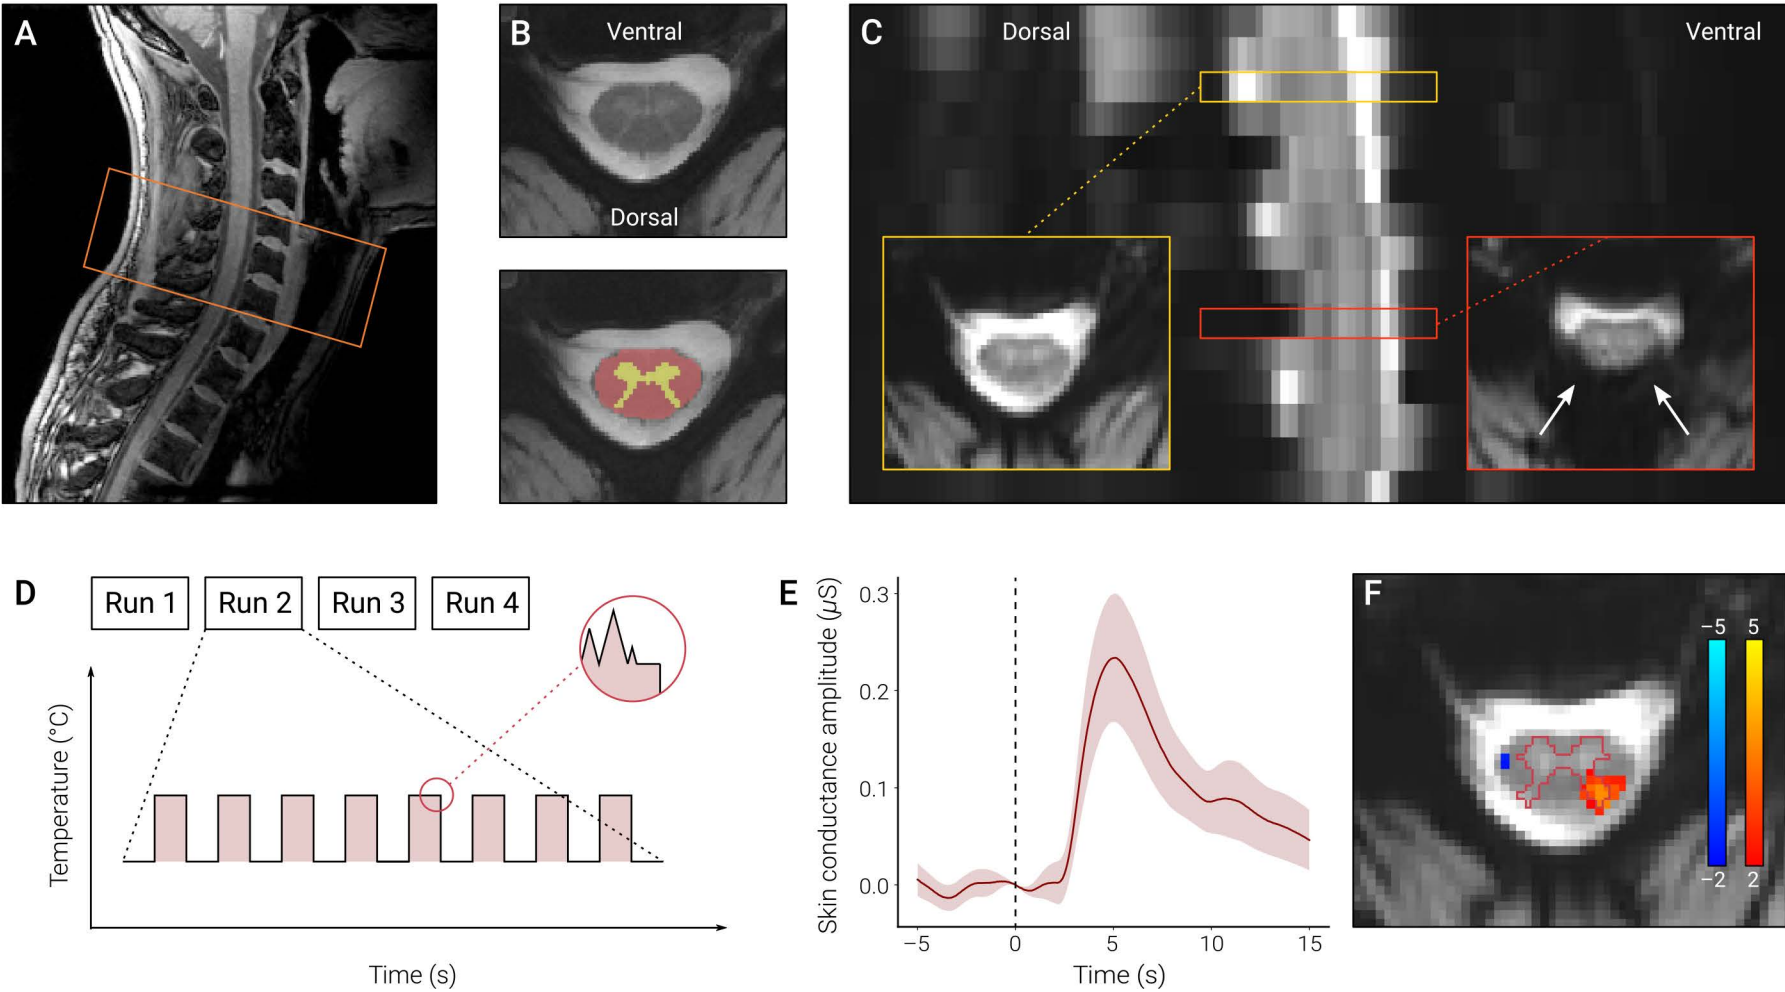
(A) Mid-sagittal section of a T1-weighted acquisition (resolution: 0.8 mm isotropic) of a representative participant, with the EPI field-of-view depicted in orange. (B) Transversal section of a structural T2*-weighted acquisition (in-plane resolution 0.38 x 0.38 mm) used to segment the spinal cord’s white matter (red) and grey matter (yellow). (C) Mid-sagittal section of transversally acquired EPI data (fifteen 3 mm-thick slices, TR = 1120 ms, TE = 23 ms, GRAPPA acceleration factor: 3, in-plane resolution: 0.75 x 0.75 mm), with insets depicting slices with adequate data quality (yellow) and insufficient data quality (red; signal loss indicated by arrows). (D) Experimental paradigm (4 runs), consisting of a 30 s ON-OFF block design using eight painful heat stimuli (with superimposed pseudorandom heat-spikes of different amplitude, frequency 1 Hz). (E) Painful heat stimulation resulted in prominent autonomic nervous system activation as assessed by concurrently recorded skin conductance responses. (F) BOLD response to painful heat stimulation at the level of a single participant, with colour bars indicating t-values. The response is overlaid on the mean functional image, with activation being present in the dorsal horn ipsilateral to the stimulation side and the activation peak falling into the individually segmented grey matter. Please note that all data come from the same participant.
